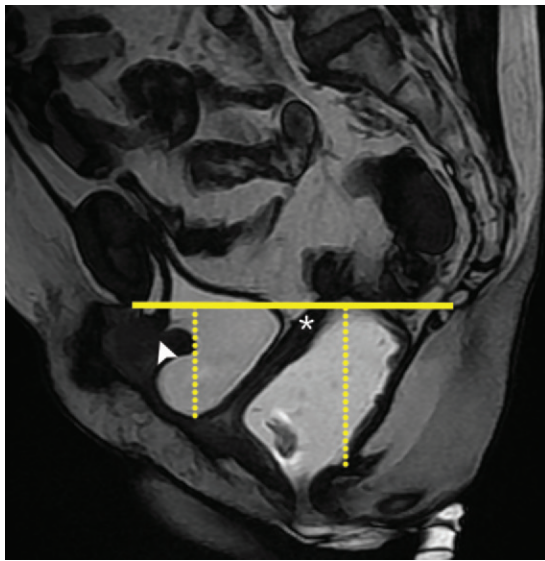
Pelvic organ prolapse in a 68-year-old woman with stress urinary incontinence and a bulging perineal mass. The patient had a history of hysterectomy. Sagittal FIESTA MR image obtained at maximal effort during defecation shows a severe cystocele (short dotted line) and angulation of the urethral axis (arrowhead) with resultant urethral hypermobility in the anterior compartment. In the middle compartment, an apical prolapse is seen (*). In the posterior compartment, marked signs of pelvic floor relaxation include descent of the anorectal junction (long dotted line) and angulation of the levator plate. A small asymptomatic anterior rectocele also is present. Solid line = PCL.
